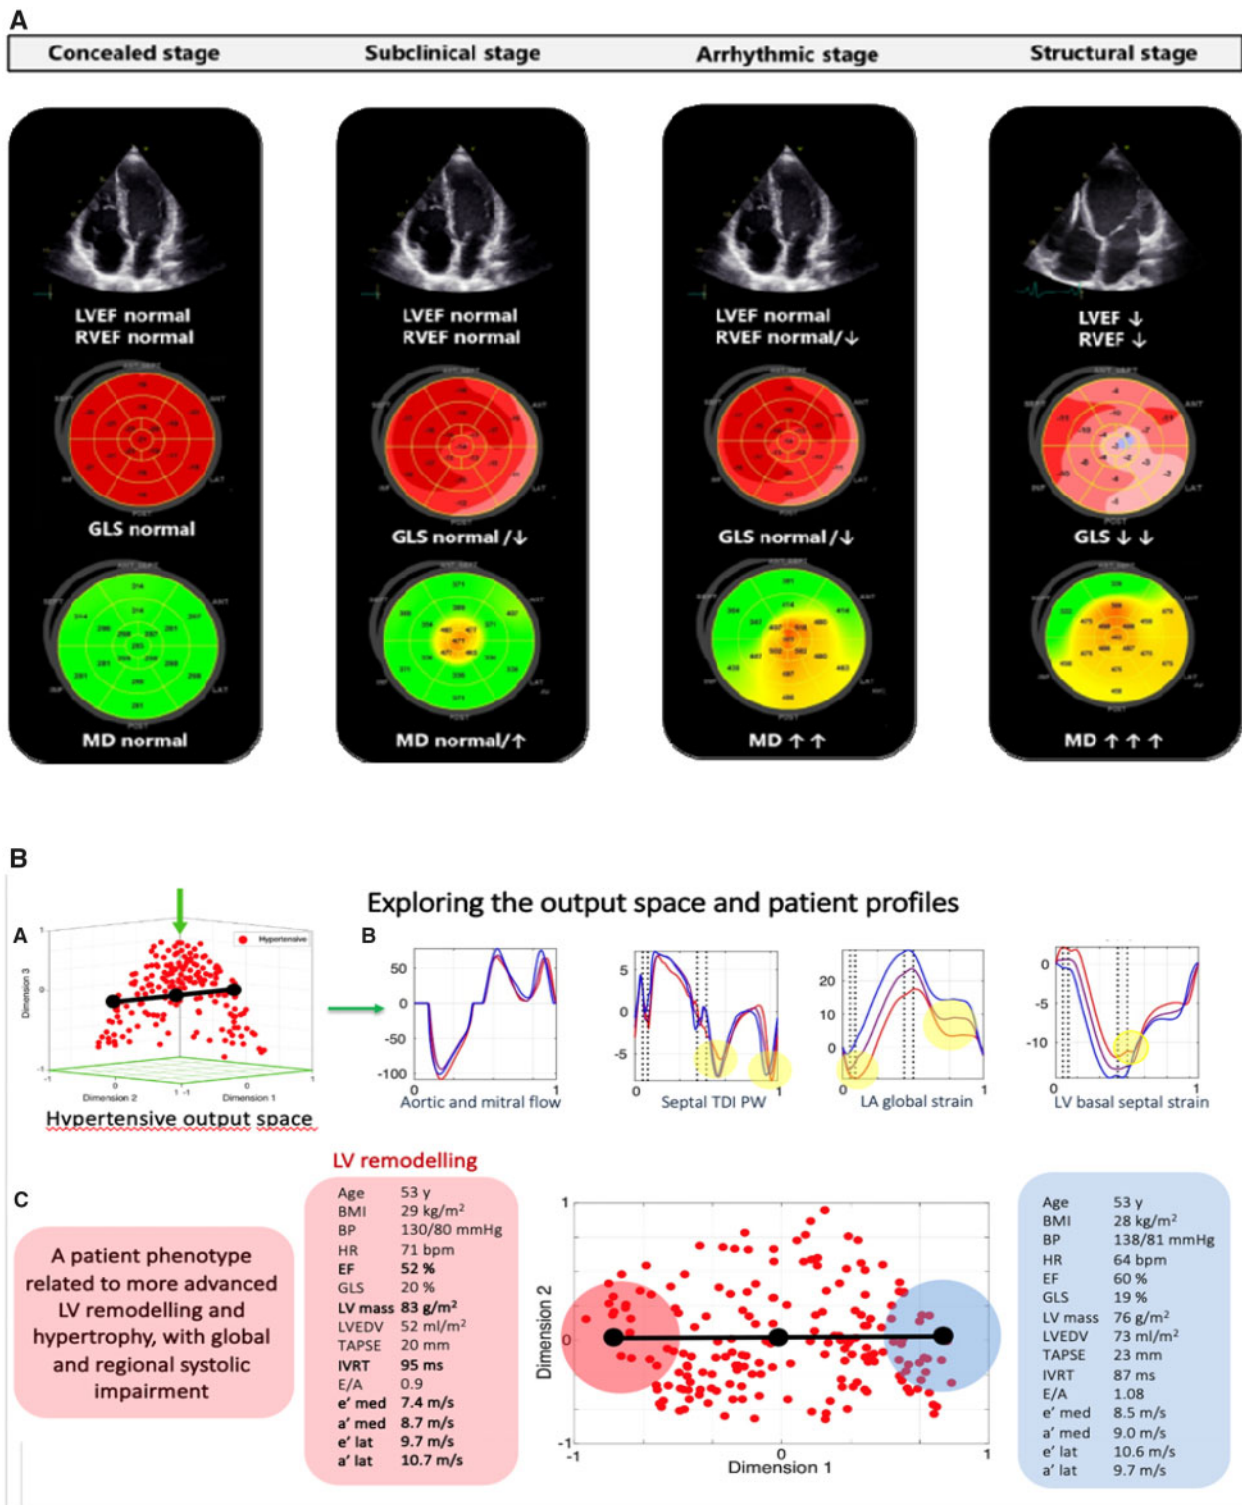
(A) Classification of PLN (Phospholamban) mutation (R14del) carriers on the basis of deformation characteristics. Pre-symptomatic stage is differentiated from concealed stage by means of decreased GLS and mechanical dispersion. LVEF, left ventricular ejection fraction; RVEF, right ventricular ejection fraction. (B) Exploration of the hypertensive output space and patient profiles from the output space. (A) Hypertensive output space, (B) extraction of individual measurements, and (C) exploration of individual patient profiles. Modified from Sanchez-Martinez et al.³⁵ LA, left atrial; LV, left ventricular; PW, pulsed wave; TDI, tissue Doppler imaging.
